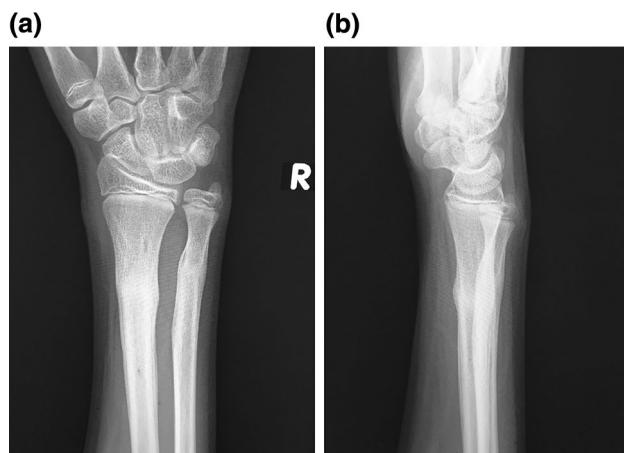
Plain radiography on the final follow-up. Bone union of the radius and ulna was acquired without postoperative redisplacement (a: A-P view, b: lateral view)
